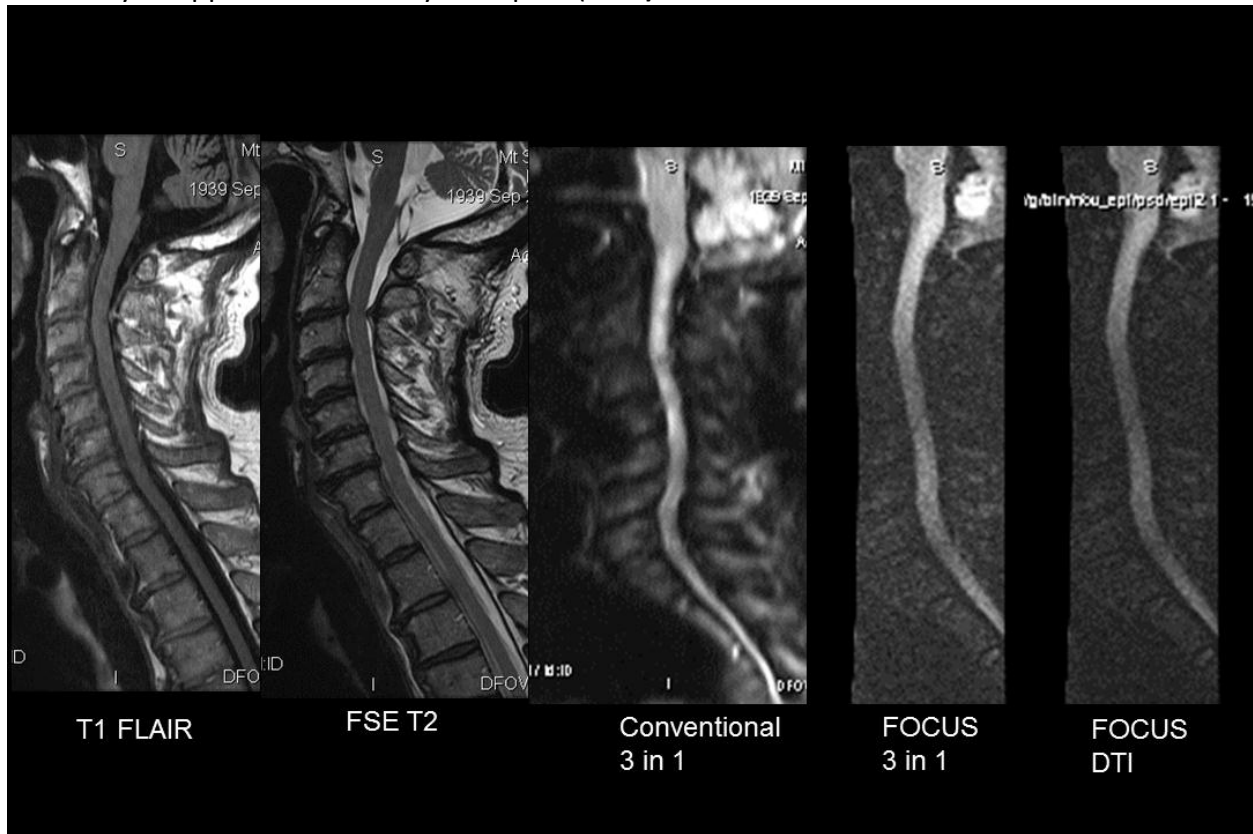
Restricted FOV EPI DWI (FOCUS). Note the striking reduction of distortion and high spatial resolution.
